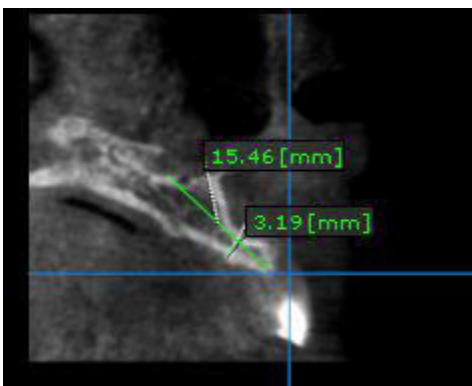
b)Saggittal section of CBCT
